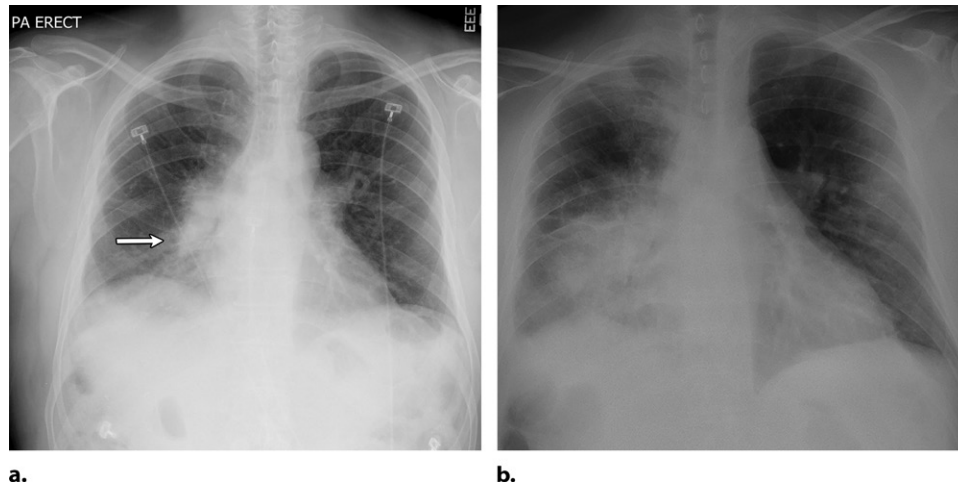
Legionella pneumonia in a 58-year-old man with occupational exposure to a contaminated water source from crawling through vents at a refrigeration plant. (a) Initial chest radiograph obtained at onset of symptoms shows a right infrahilar and basilar consolidation (arrow). (Fig 2a reprinted, with permission, from reference 100.) (b) Follow-up chest radiograph obtained 2 days later shows progression of the right basilar consolidation and new consolidative opacities in the right upper lobe and periphery of the mid upper left lung, findings consistent with progressive multilobar pneumonia.
